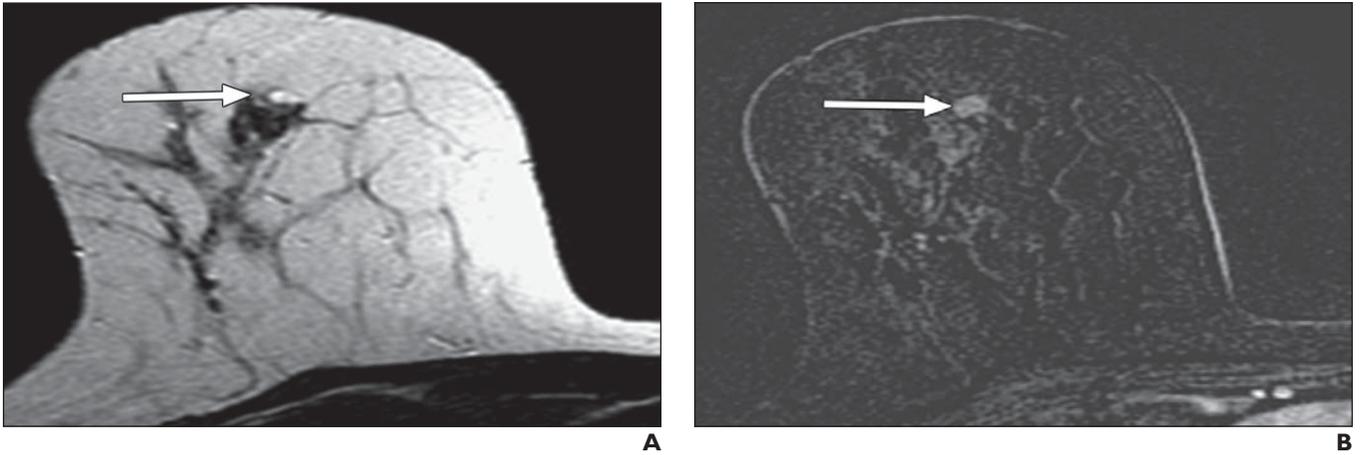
Simple cyst in 42-year-old woman who presented for high-risk screening breast MRI. A and B, T1-weighted (A) and T2-weighted (B) MR images show uniformly hyperintense signal in two adjacent simple cysts. C, Contrast-enhanced subtraction image shows thin rim of smooth enhancement, indicative of inflammatory reaction.
